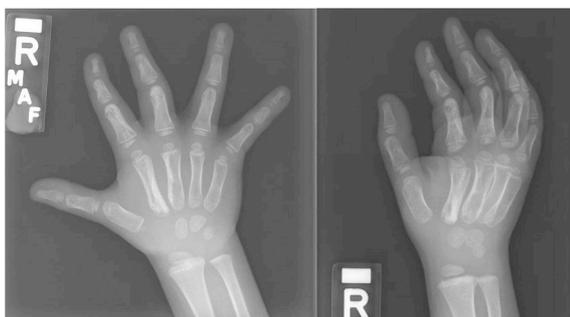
A, B. Initial radiographs of a skeletally immature right hand with (A) anteroposterior and (B) oblique views demonstrating mild rotation of the index finger and slight radial deviation of the long finger.
